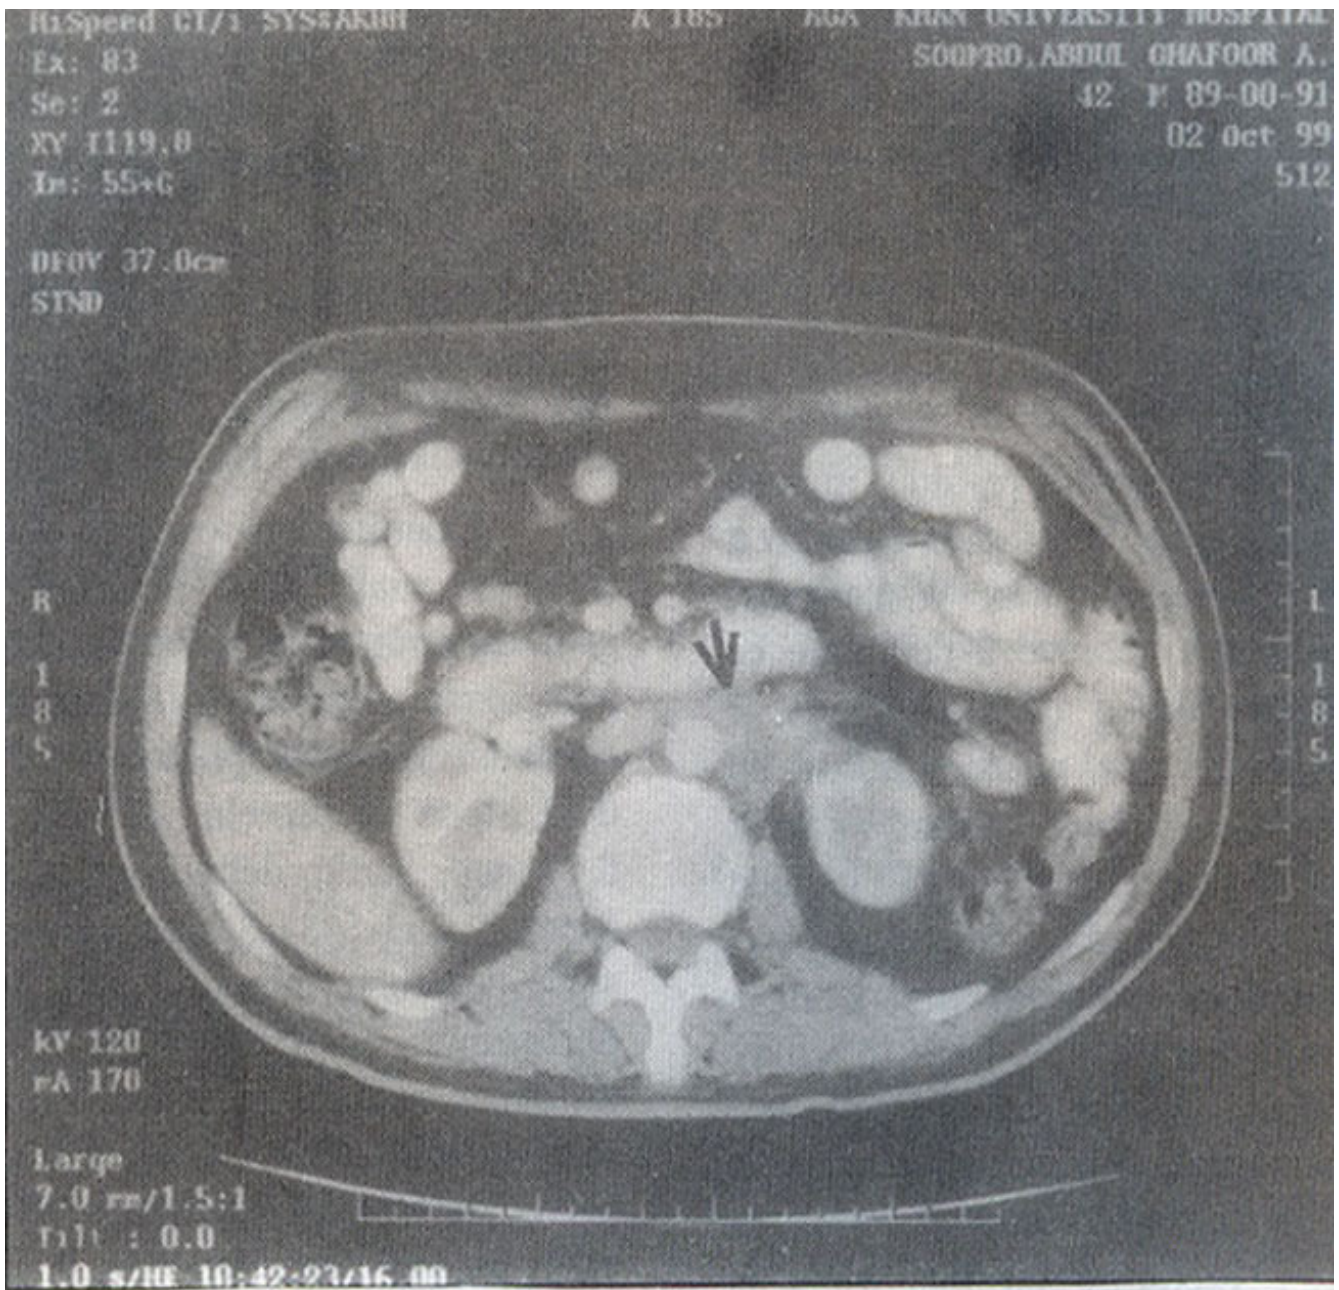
Post chemotherapy CT scan abdomen showing a 4 2x2.5 cm residual mass in para-aortic region (arrows).
